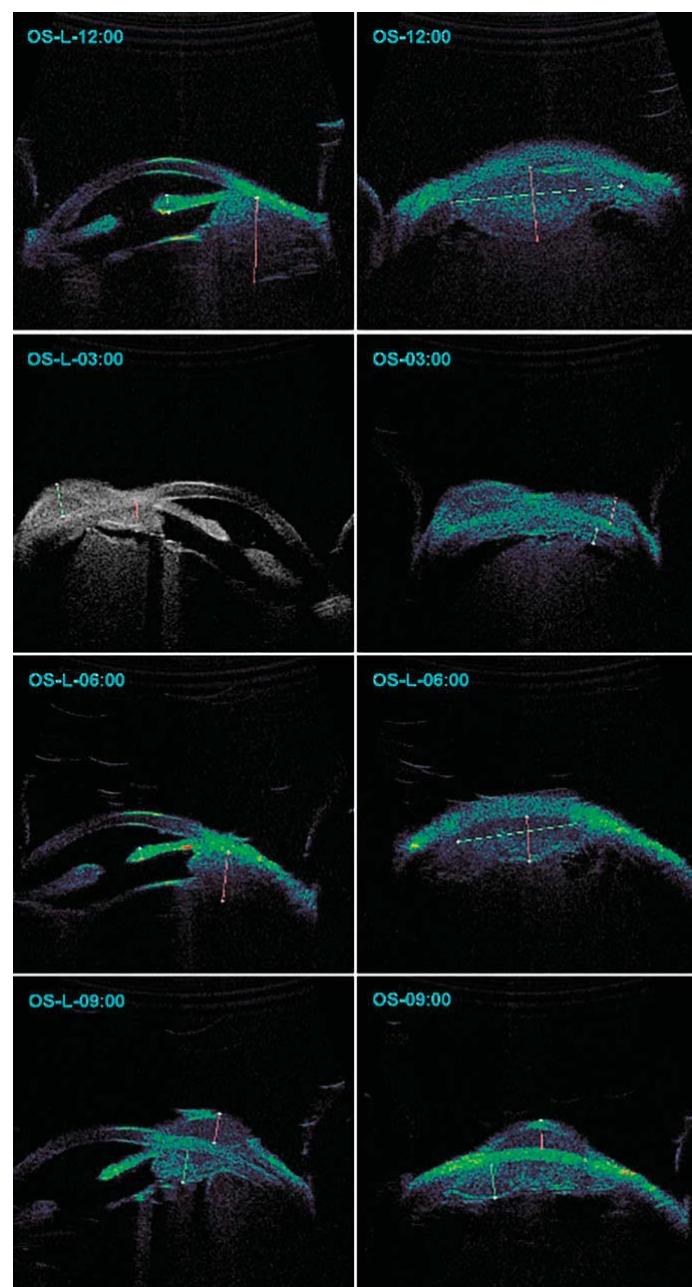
A 35 MHz high-frequency ultrasound examination was performed in movie mode. Selected still images were recorded and collected at sequential clock hours (12:00, 3:00, 6:00 and 9:00). They reveal the tumor's anterior, ring configuration, multiple epibulbar extrascalar extensions as well as the tumors moderately to low internal reflectivity (inside and outside the eye)
